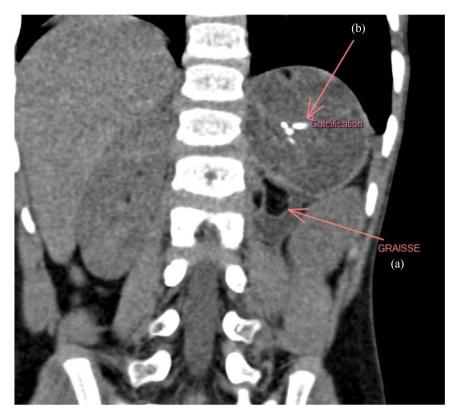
CT-scanned corneal section without injection of contrast product highlighting a fatty component (a) and calcifications within the left adrenal mass (b).
